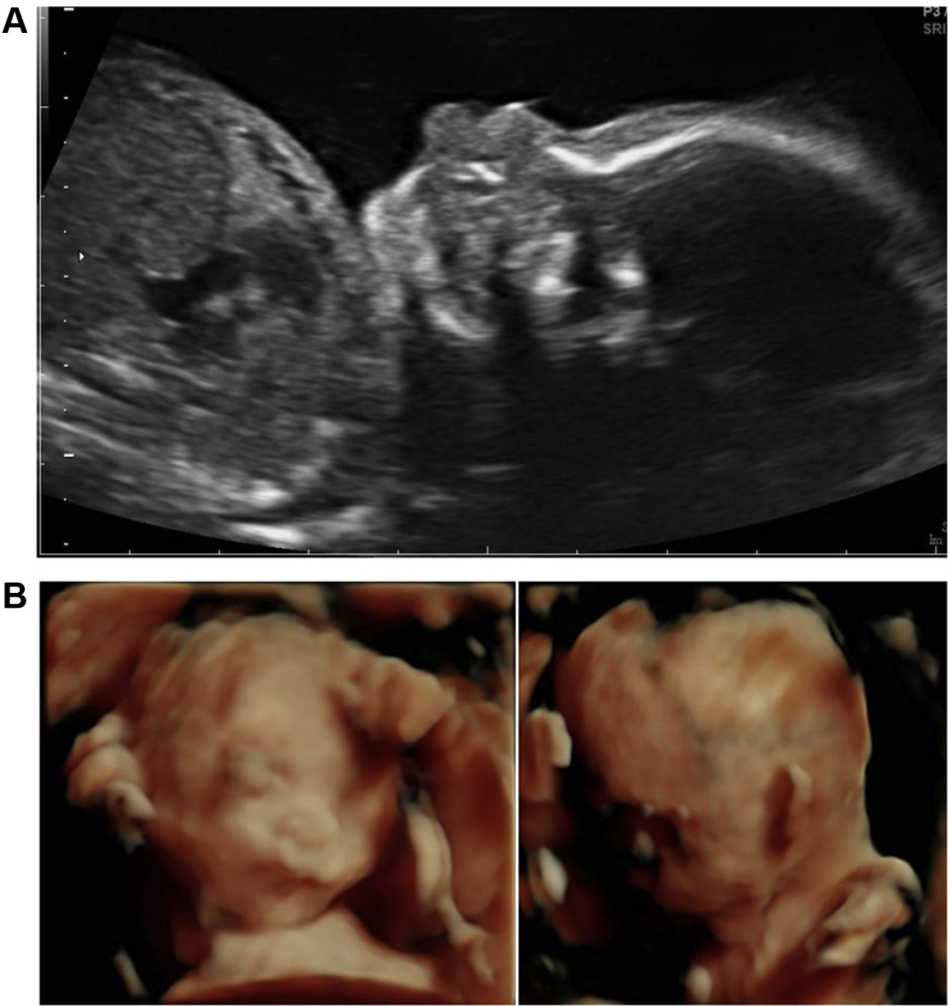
Craniofacial dysmorphism on (A) two-dimensional and (B) three-dimensional ultrasound.
